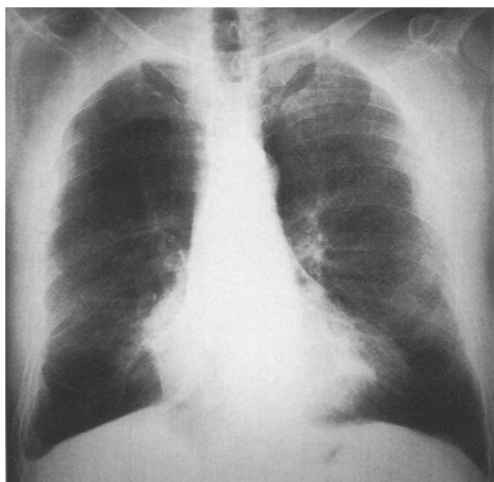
Plain chest radiograph : bilateral pleural thickening with a visceral (or diffuse) type on the right side (costophrenic angle obliteration)
